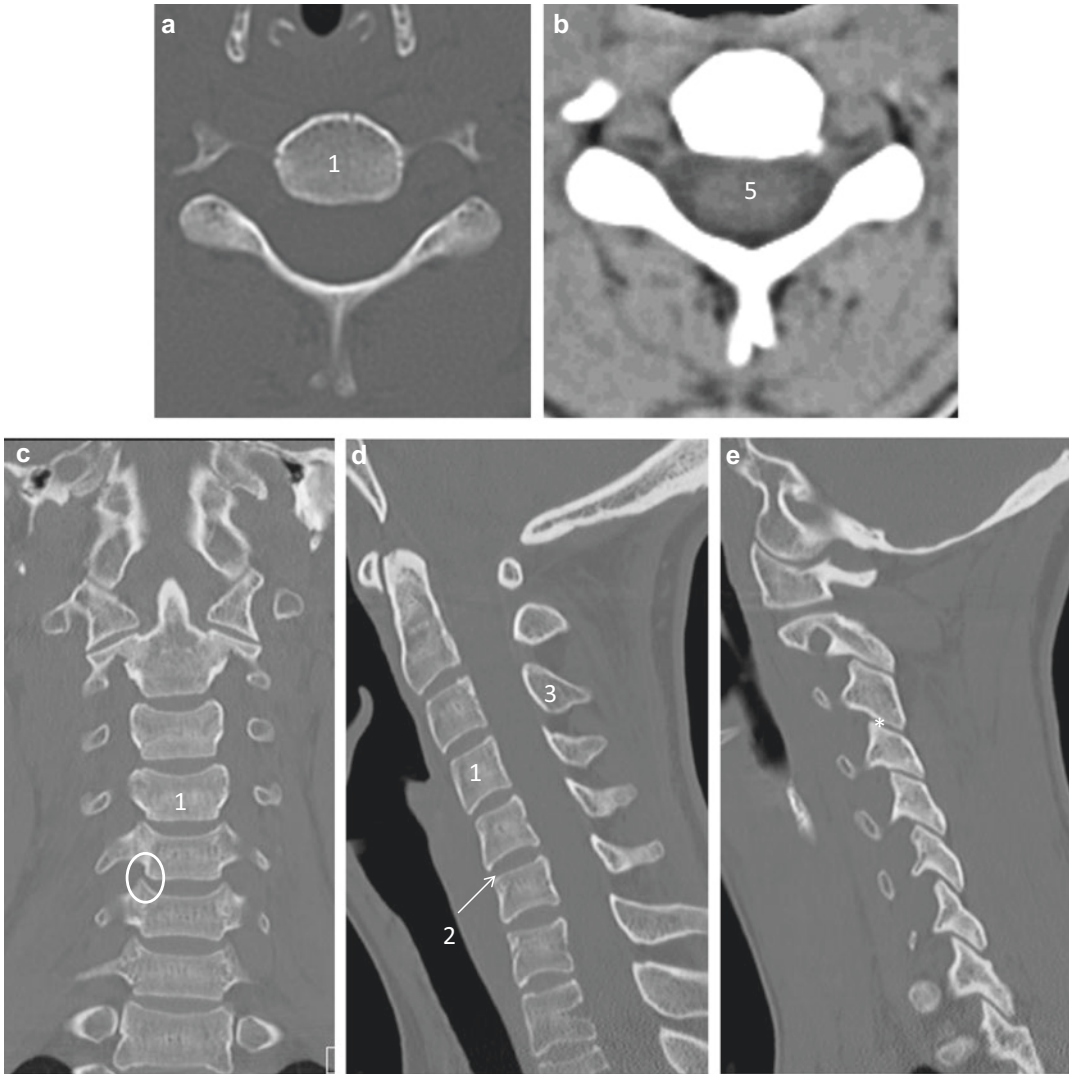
Representative CT images of cervical spine. (a) Axial bone. (b) Axial soft tissue. (c) Coronal. (d) Midline Sagittal. (e) Parasagittal. (1) Vertebral body; (2)
